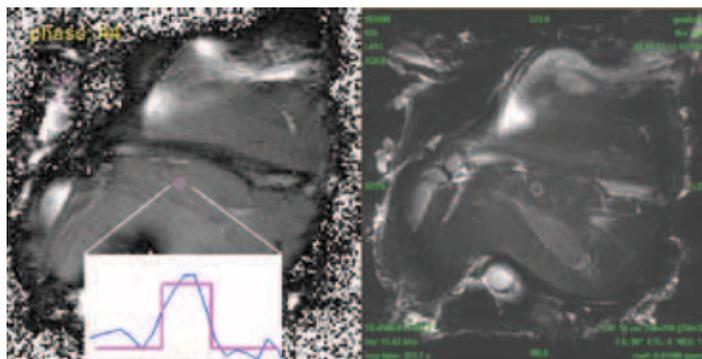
(Left) PSIF-based and FISP-based images were averaged in the final results, for improved SNR. The inset shows a profile of the image signal (blue) and the 240 TEM43°C contour (magenta) through the lesion. (Right) A T2 weighted image was acquired right after the ablation. Good agreement was found between the bright region (left), the thermal dose contour (left) and the post-sonication T2-weighted image (right).
